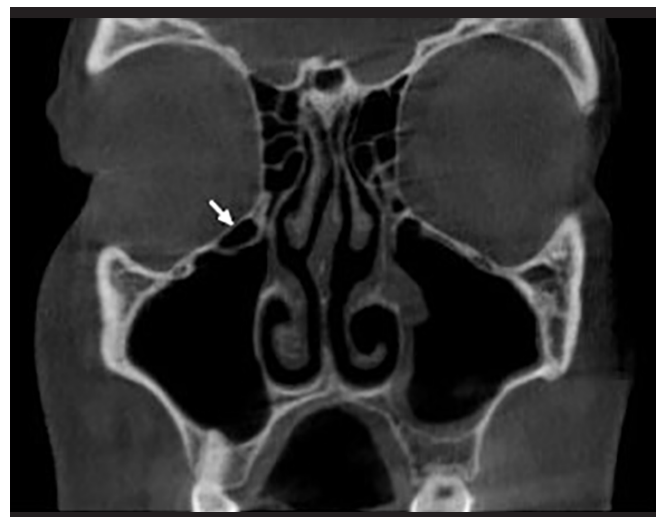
Coronal (a) and axial (b) CBCT images show right and left accessory maxillary ostium (white arrows). Coronal CBCT image demonstrates mucosal thickening localized in the left maxillary sinus.
